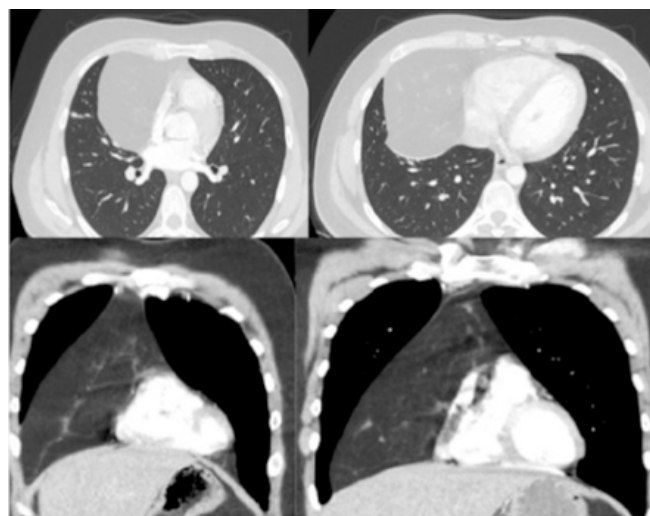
Preoperative contrast-enhanced computed tomography.
